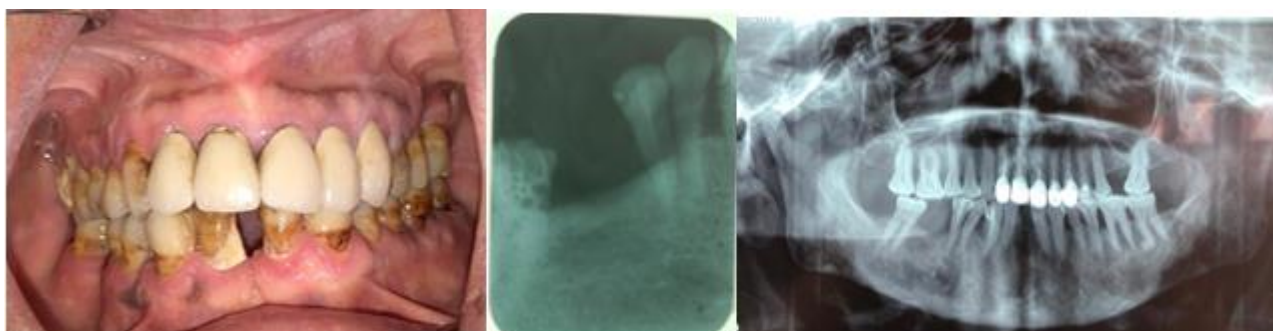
Intraoral view and radiographs showing poor oral hygiene and multiple defective endodontic treatment.
